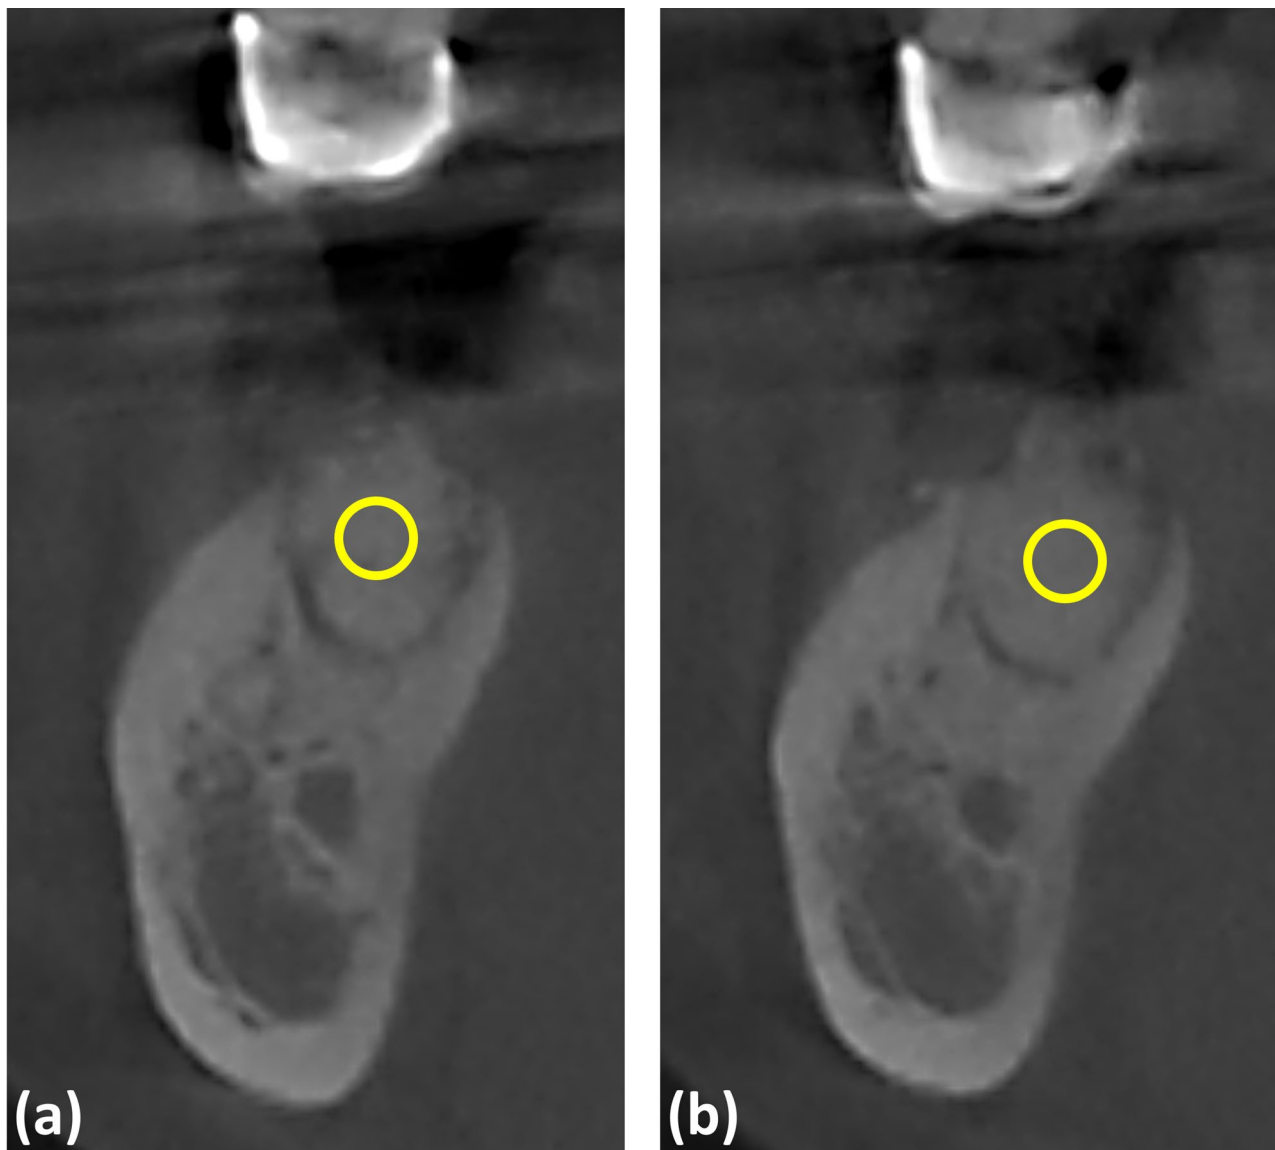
Representative sagittal CBCT images showing the region of interest (ROI) placement. a Sagittal slice obtained immediately after tooth extraction and grafting, passing through the mesio-distal center of the extraction socket. b Corresponding sagittal slice at 4 months post-socket preservation. The yellow circle indicates the ROI, defined as a 3-mm-diameter circular area positioned in the central portion of the grafted socket, excluding native surrounding bone. Identical anatomical positioning of the ROI between time points was ensured by image registration, with the same slice used for both baseline and follow-up measurements
